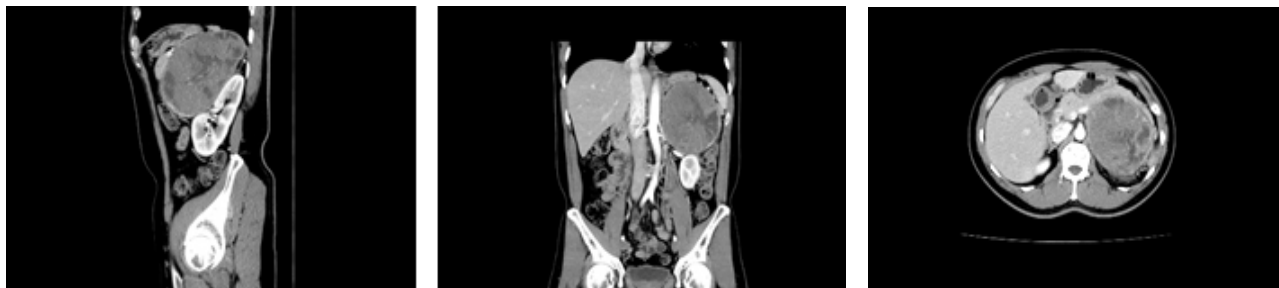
CT Scan appearance of giant adrenal tumor.
